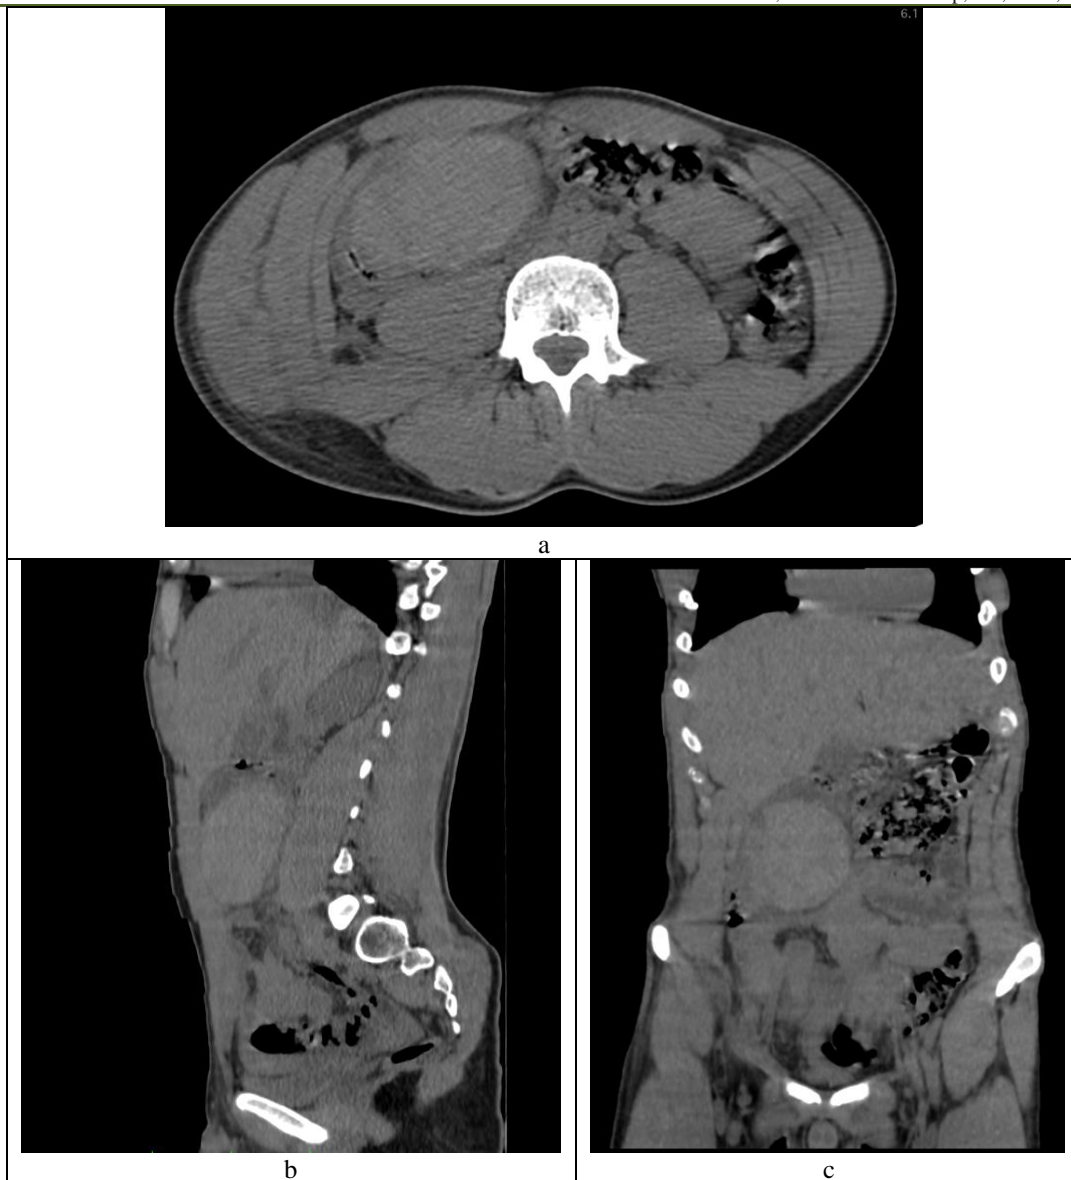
PDC-free abdominal-pelvic CT scan, axial (a), sagittal (b), coronal (c) sections, showing isolated colonic intramural hematoma
